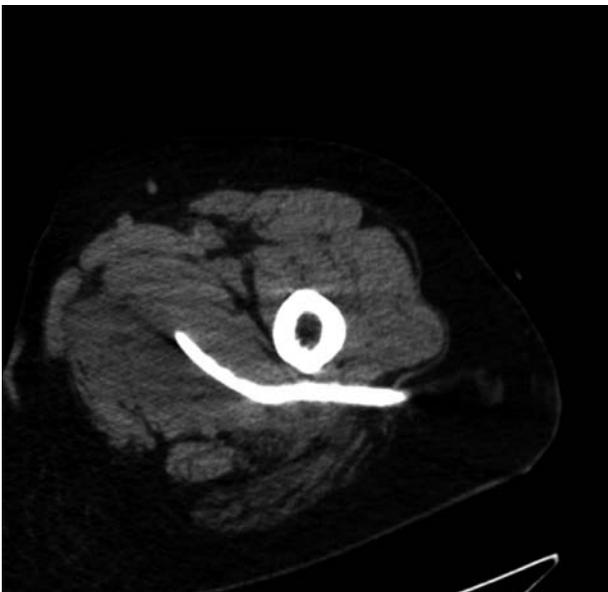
CT-guided drainage, left upper leg.
